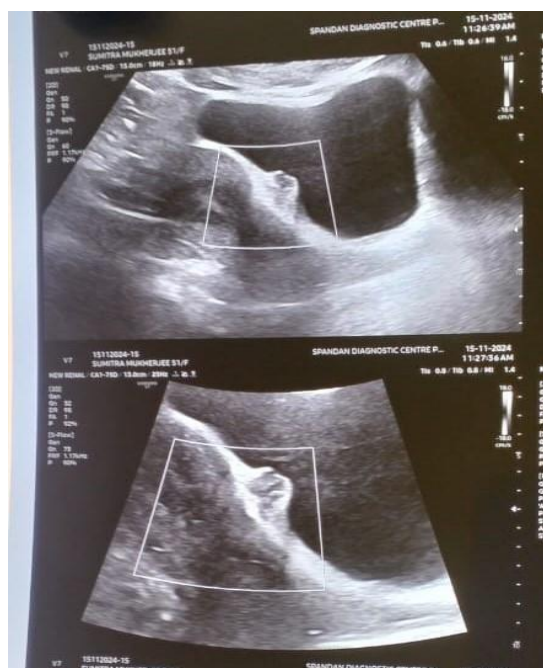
Ultrasonography of kidney ureter bladder showed a hypoechoic cystic lesion (18.7 x 10.8 mm) with mild
